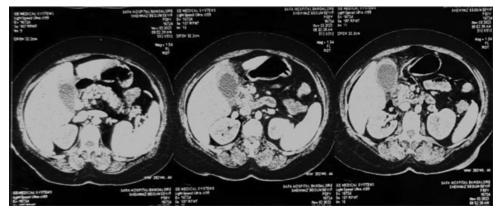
Computed tomography of the upper abdomen demonstrates a thickened gallbladder wall with echogenic debris and pericholecystic fat stranding
